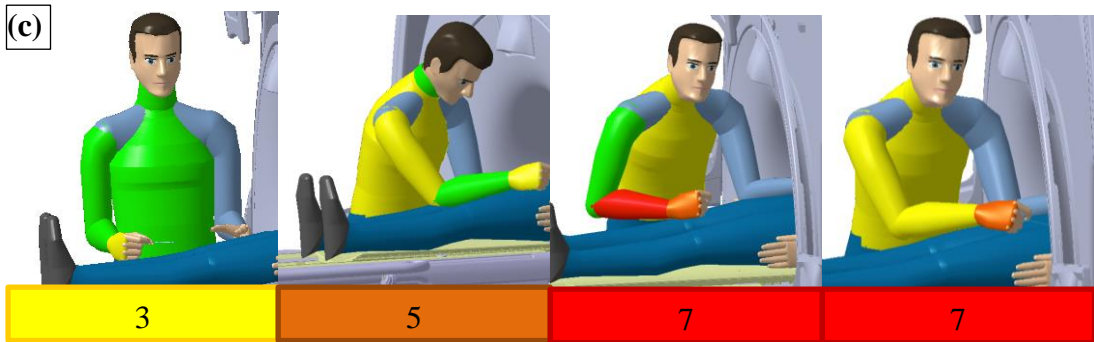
Screenshot of key postures 1 – 4 defined during a MRI-guided procedure for clinician BC (first row (a)), equivalent postures modelled in Delmia V5R20 for the 1.5T GE Signa MRI scanner (second row (b)) and the 3T GE Discovery MRI scanner (third row (c)) (GE Healthcare, Waukesha, WI, USA). Below the virtual environments, global scores given by the RULA analysis are shown.
